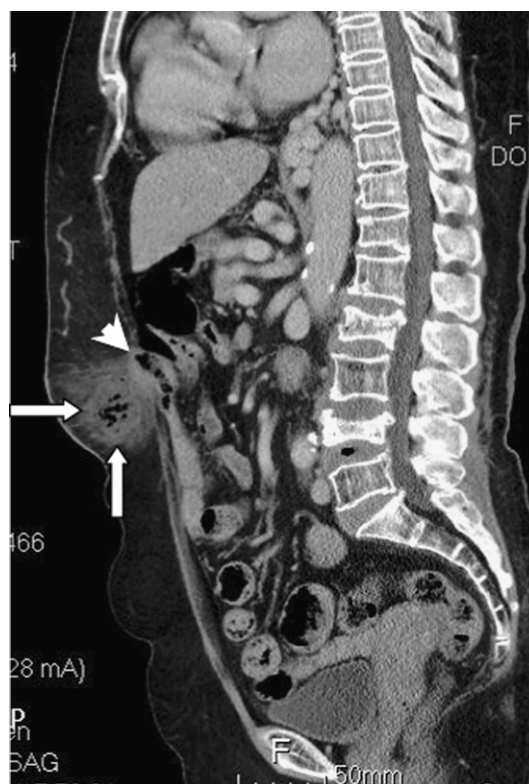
A sagittal reformatted contrast-enhanced computed tomographic image at mid-abdomen, showing an incarcerated incisional hernia at the previous incisional site (arrowhead), with abscess formation (arrows).
